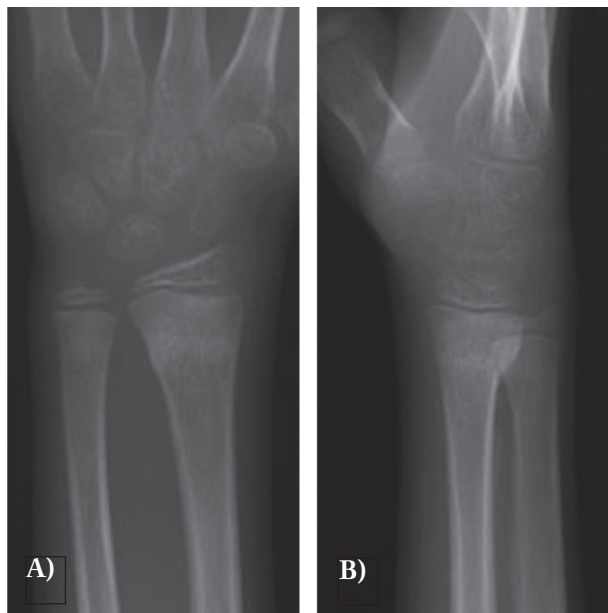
A, B. Final X-ray three weeks from trauma (bone healing)
